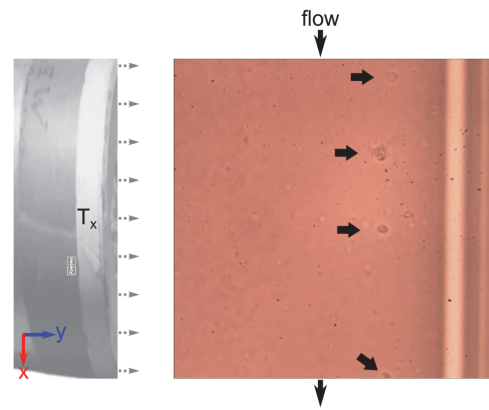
White blood cells (arrows) lined up at positions distal to the ultrasound transducer T_x . Red blood cells have accumulated proximal to the transducer. The field of view corresponds to an area of $211 \times 211 \mu\text{m}^2$ in the plane $z=0$.
